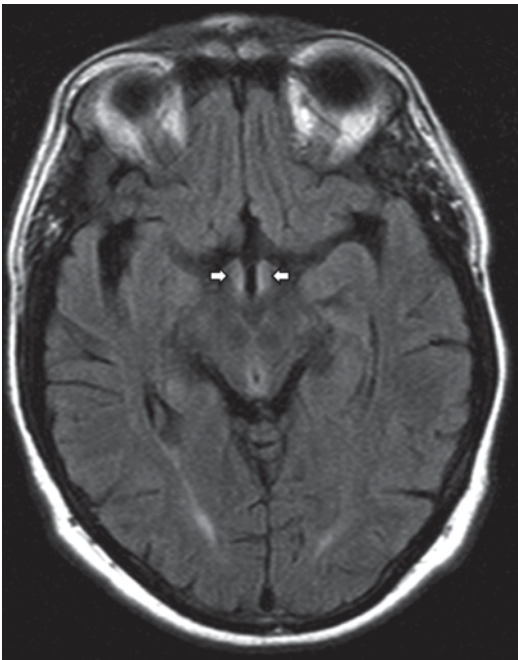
Axial MRI FLAIR sequence of a 50-year-old alcoholic who presented with confusion, ataxia, nystagmus, and diplopia, showing bright signal in the mammillary bodies (*arrows*). (Courtesy of Dr. Blaine Hart)
